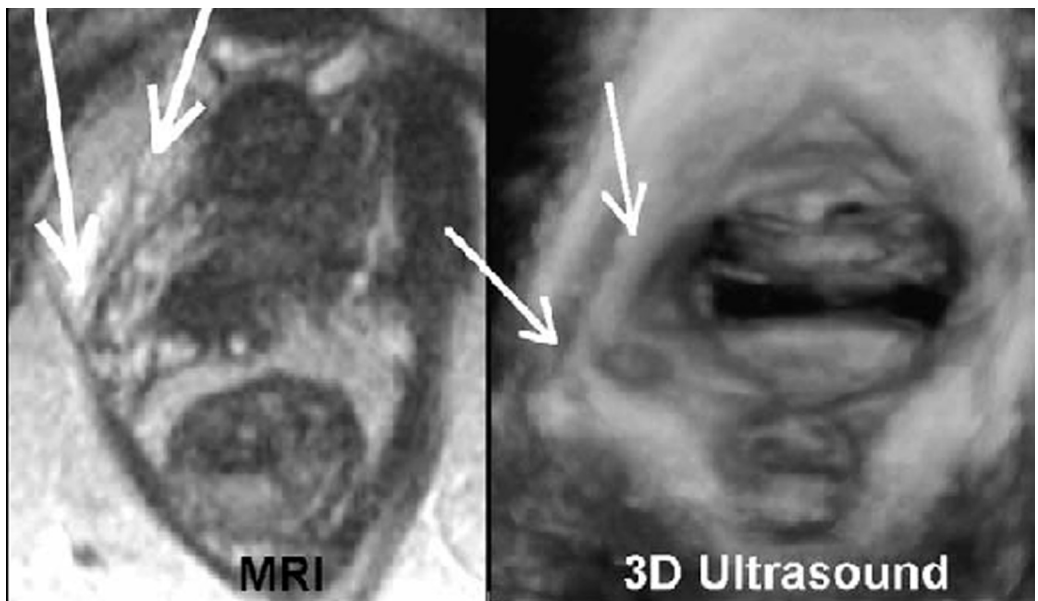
Detachment/avulsion of the insertion of the right pubovisceral muscle (arrows) on MRI (left) and 3D pelvic floor ultrasound (rendered image, right). These images were taken in different patients but represent a typical injury as seen on MRI and ultrasound. MRI image courtesy of Dr Ben Adekamni, Plymouth, UK.
